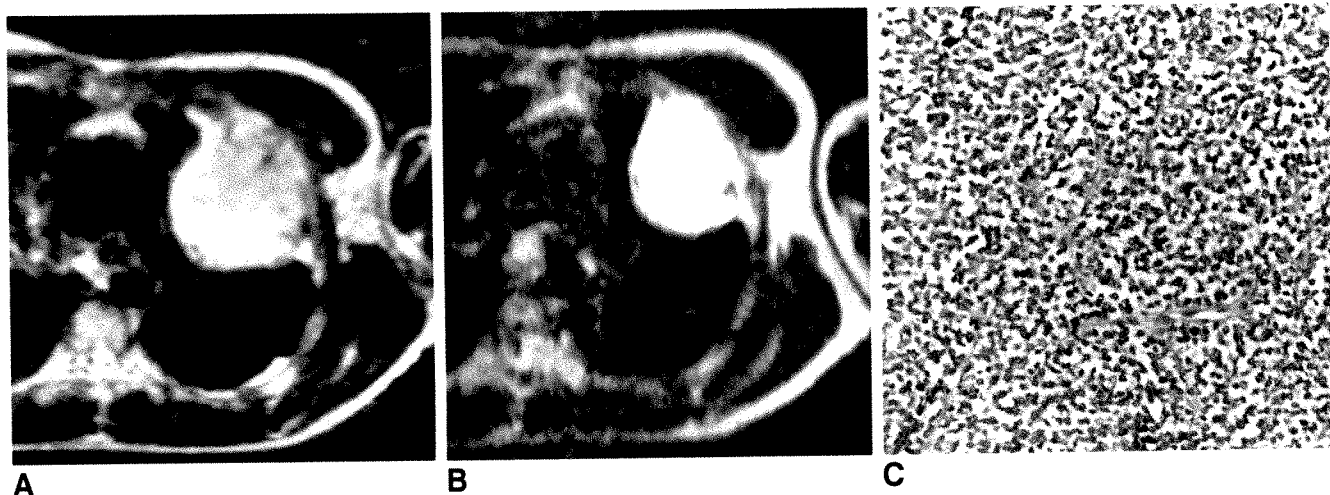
Ewing sarcoma of fourth left rib (case 2) on T2-weighted MR images (2000/100).
